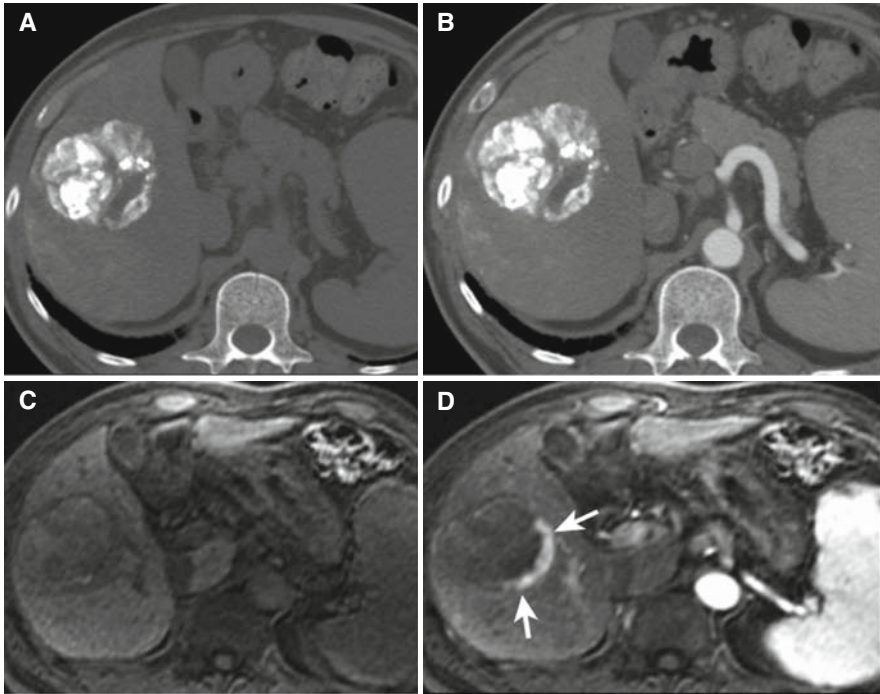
HCC following chemoembolization, with small remaining viable portion. A. Unenhanced CT shows embolic material within HCC. B. Contrast-enhanced CT does not show any visible enhancement of tumor. C. Unenhanced MRI shows that HCC is of similar intensity to liver. D. Arterial phase MRI shows viable hypervascular tissue at the periphery of HCC (*arrows*).
